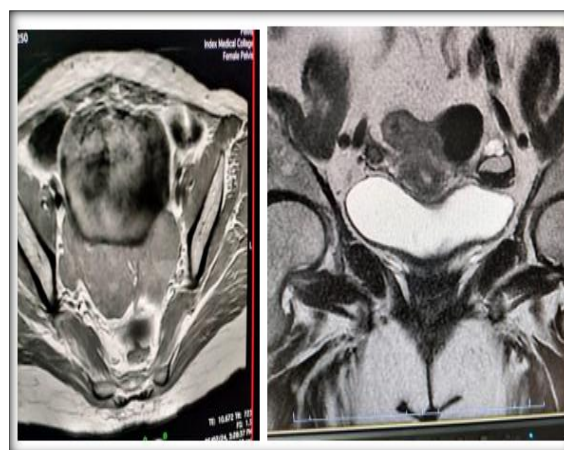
SAGITTALT2-weighted images show a multiloculated cystic ovarian tumour with intermediate to high signal intensity of the loculi and solid parietal component. SAGITTAL contrast-enhanced T1-weighted image demonstrates enhancement of the wall and of the solid component. HPE shows neoplastic glands lined by columnar cells of intestinal-type with mucinous secretion
